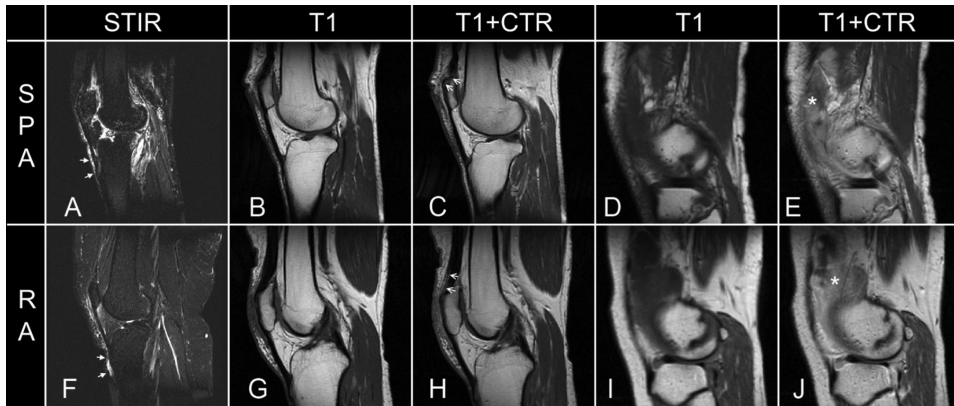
Representative magnetic resonance (MR) images of spondyloarthritis (A–E) and patients with rheumatoid arthritis (F–J). The MR images are sagittal short  $\tau$  inversion recovery (STIR) images (A and F), sagittal T1 weighted images before (B, D, G and I) and after (C, E, H and J) contrast enhancement. A and F show perienthesal fluid/oedema at the patellar tendon insertion at the tibial tuberositas (closed arrows). C and H show subtle enhancement of the quadriceps tendon attachment (open arrows). E and J show extensive synovial hypertrophy and enhancement (\*) in the lateral compartment of the knee.
